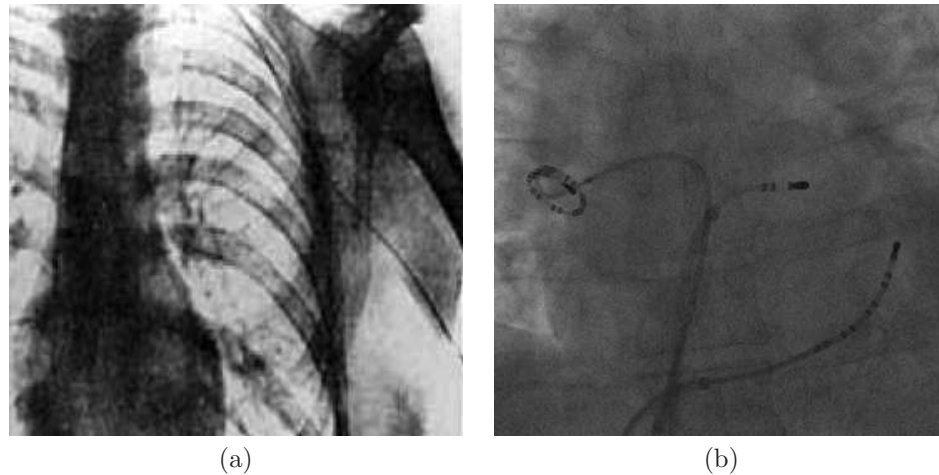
(a) X-ray picture of the first catheter inserted into the human right atrium. Reproduced with permission from [48]. Copyright The Society of Thoracic Surgeons. Published by Elsevier Inc. (b) A recently taken X-ray picture of a patient undergoing an RFA procedure with the CS, ablation and CFM catheters introduced into the heart.
